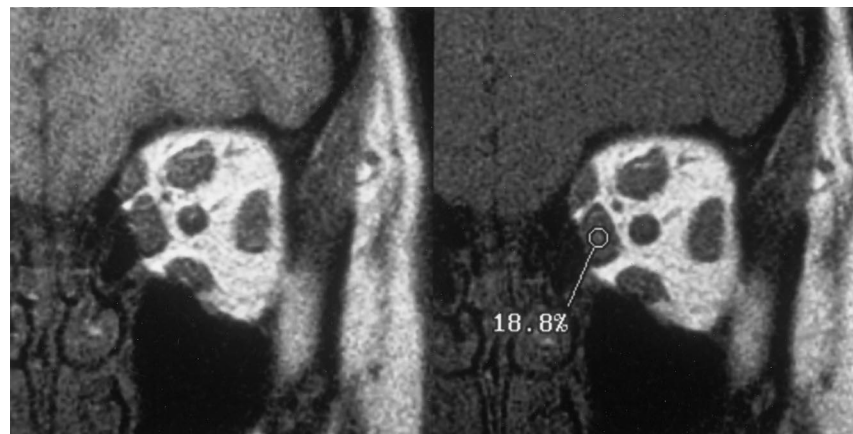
Patient with Graves' disease. T1-weighted image without (*left*) and with (*right*) off-resonance saturation pulse applied at 500 Hz frequency offset. Extraocular muscles are enlarged with reduced signal suppression compared with control subjects (compare with Fig 2). Medial rectus muscle suppression ratio measures 19%. Window width and level settings are constant.
